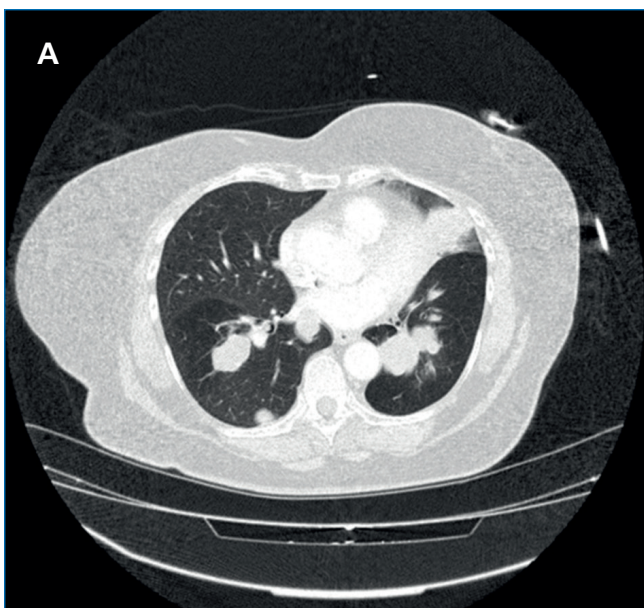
Computed tomography (CT) scan showing disease progression from cycle 24 (A) to cycle 27 (B).
